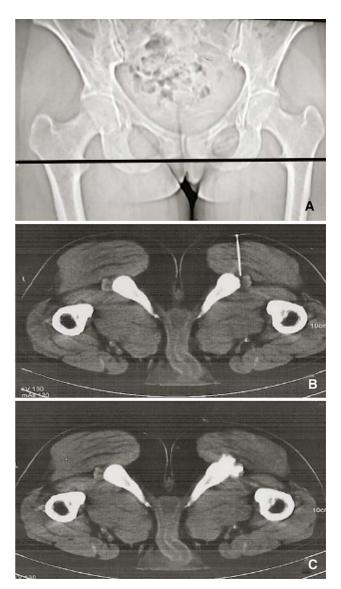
CT-guided infiltrations of the right inferior cluneal nerves: a level of the infiltration;  $\mathbf{b}$ ,  $\mathbf{c}$  infiltration through the gluteus maximus, on the lateral and inferior edges of the ischium
